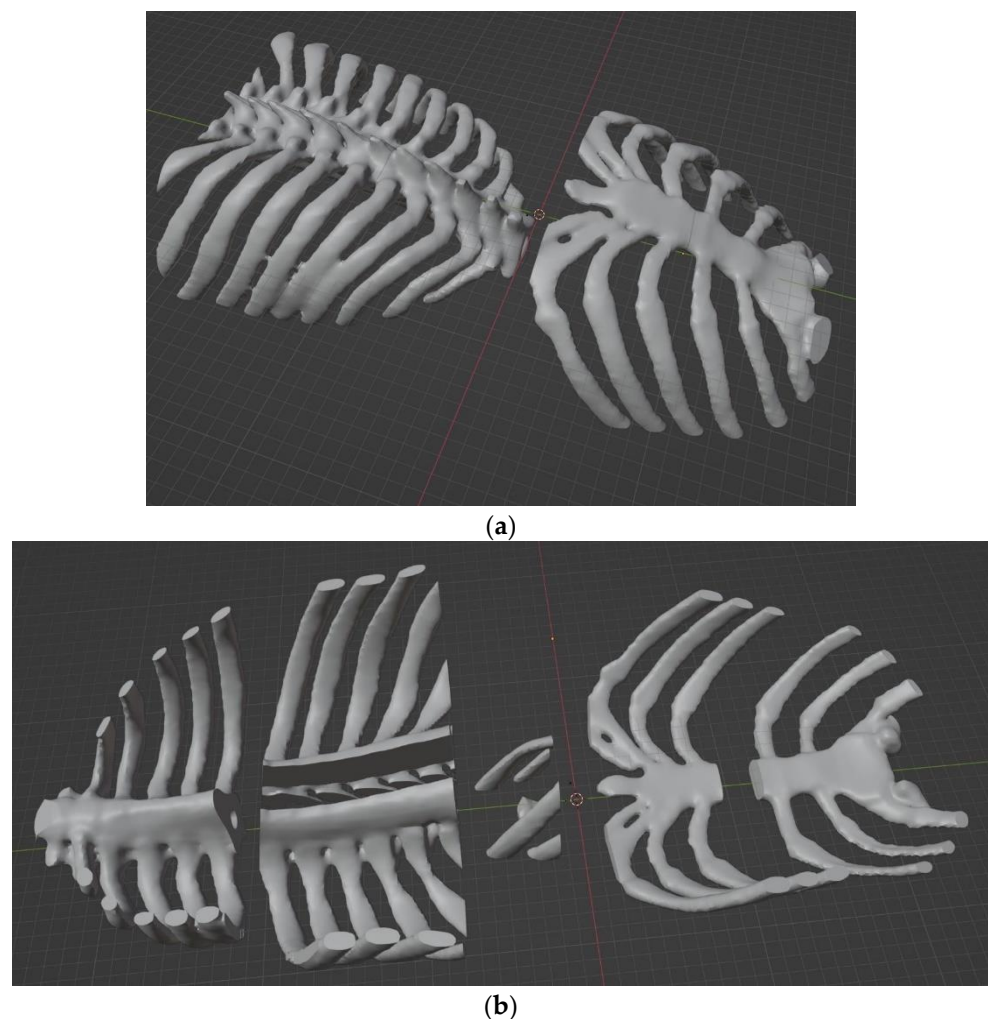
Ribcage models created from CT-scan data (a) Initial file received, produced from scan and cut in two (b) Further separated parts with modified orientation. Each of the separated parts can fit within the build volume of the printer being used.
